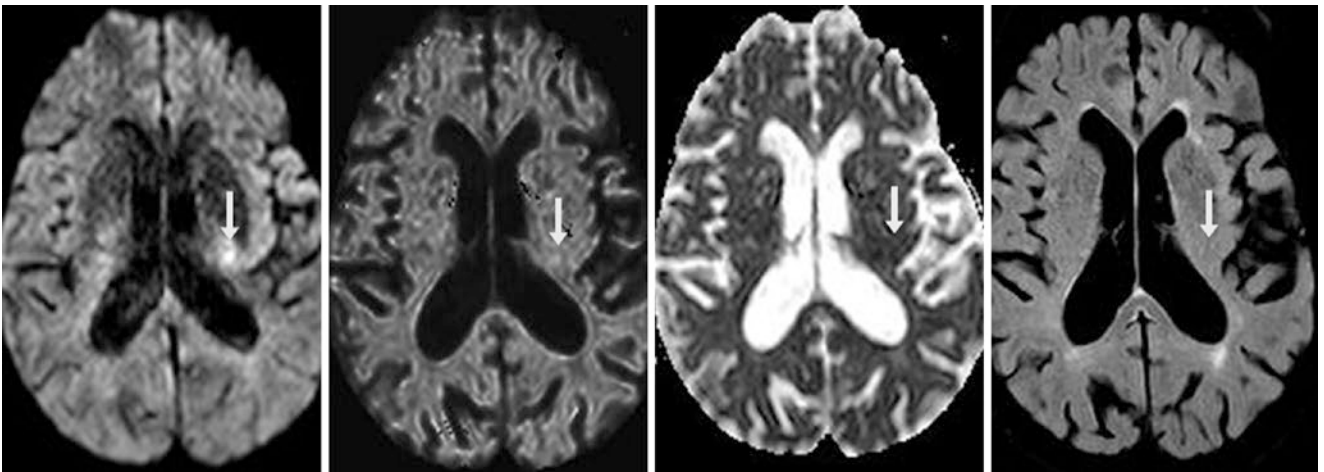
A 1.5 T MRI in a 78-year-old shows unilateral hyperintensity within the left PLIC/CST (*arrows*) on DWI (*left*). On initial review, this appeared to be a small lacunar infarct, but there was no corresponding bright signal on exponential DWI (*left middle*), which removes
